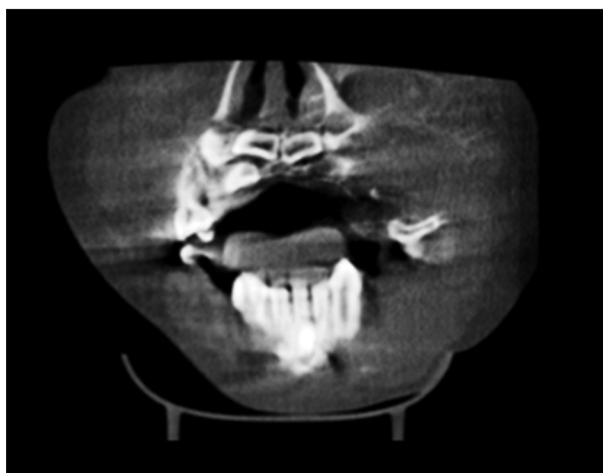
Cone beam computed tomography (coronal view) of maxillary jaw showing a lesion on the left side of maxilla of diameter 4 cm x 3 cm with irregular border and bony expansion
